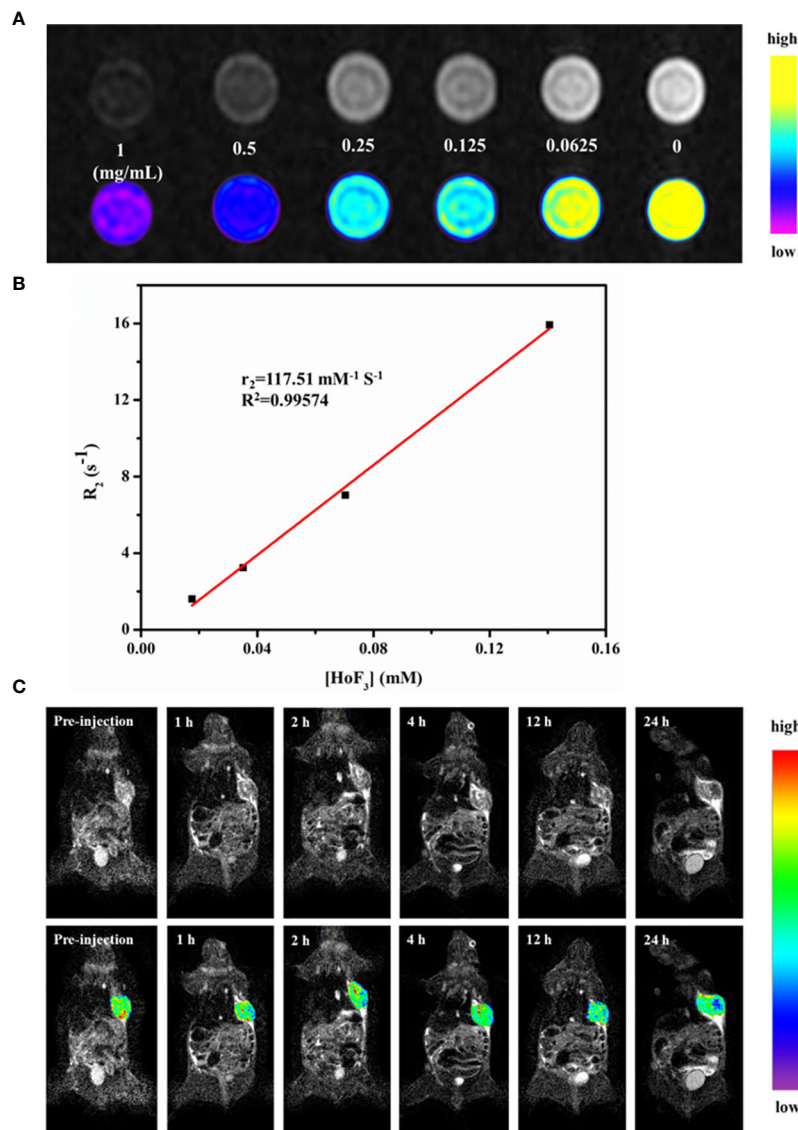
(A) *In vitro* T₂-weighted MRI images of PEG-HoF₃ NPs with different concentration; (B) The r₂ relaxivity plot of PEG-HoF₃ NPs; (C) Signal changes of tumor site in different time point before and post-injection of PEG-HoF₃ NPs.
